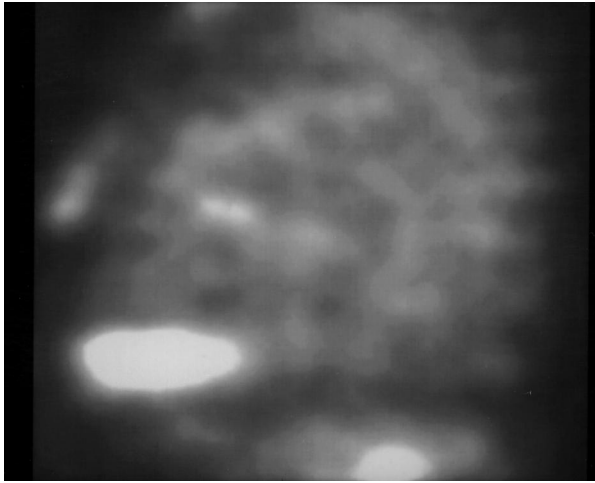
A 56-year-old patient with endocarditis of the mechanical aortic prosthetic valve. ^{99m}Tc -Fab' fragment scintigraphy (a) in the sagittal slice shows the granulocytic accumulation on the valve plane.
